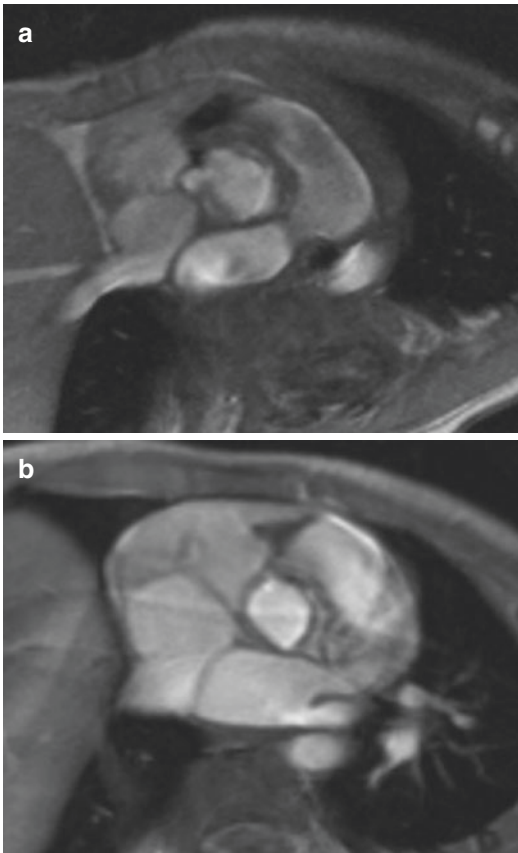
Classification of VSD based on the aortic valve acquisition. Cine FLASH MRI sequence images show in (a) a jet 10 o'clock position indicating a perimembranous VSD and in (b) at 12 o'clock position, a small subaortic outlet VSD
